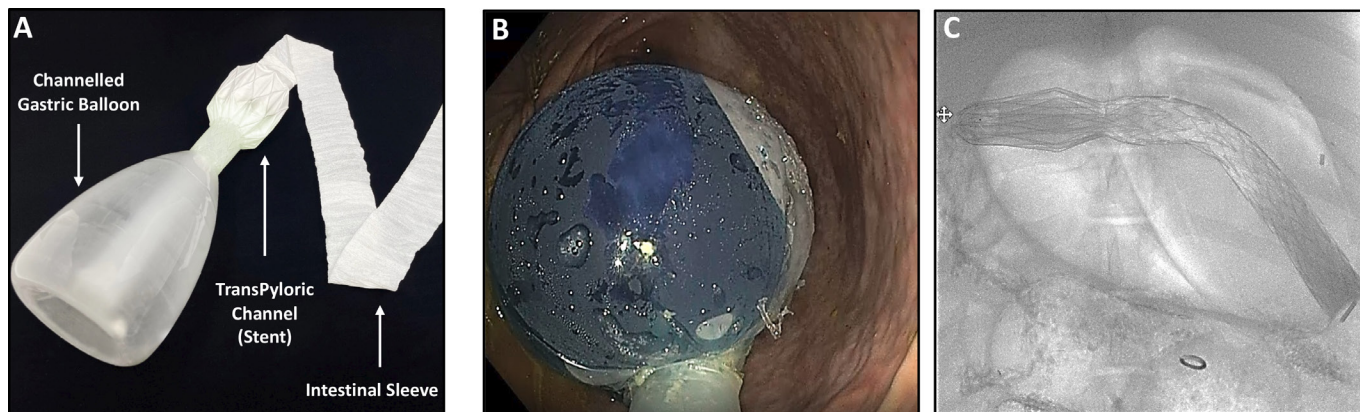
Characteristics of the Forepass device. (A) The overall structure of the ForePass device, which is composed of a silicone gastric balloon and an expanded polytetrafluoroethylene (EPTFE) intestinal sleeve. A nitinol stent-like funnel, which traverses the balloon, connects to the sleeve. The transpyloric stent, coated by EPTFE, helps to improve device stability. (B) An endoscopic image of the proximal end of the ForePass device, including the inflated gastric balloon. The balloon's colour is due to methylene blue added to the saline solution used to inflate the device. (C) An X-ray fluoroscopy image of the ForePass device positioned in the stomach and proximal gut. The balloon component of the device is placed in the stomach, while the transpyloric stent and intestinal sleeve are located further down, past the pylorus.
